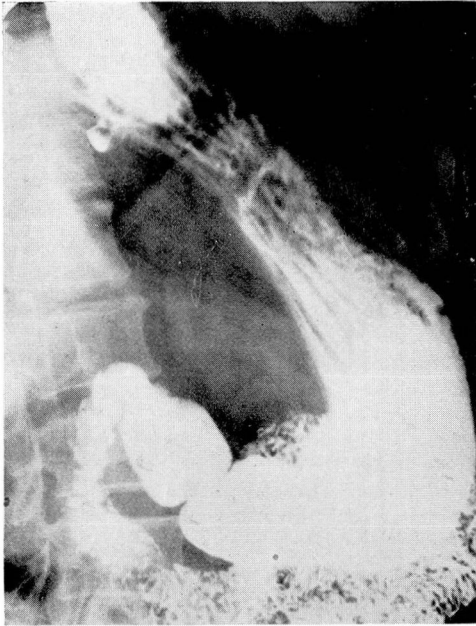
Para-esophageal hiatus hernia in 63 year old white woman presenting typical peptic ulcer symptoms. Well-defined gastric ulcer apparent in the hiatus hernia. Complete relief of all symptoms followed transthoracic repair.
